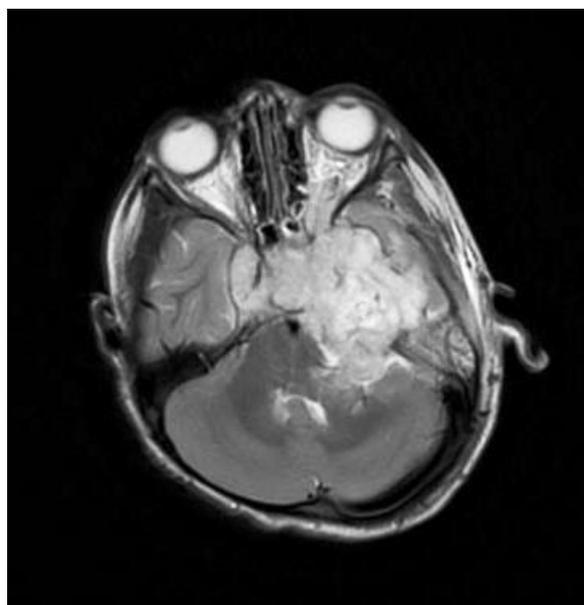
MRI images showing intra- cranial extension of the Rhabdomyosarcoma
